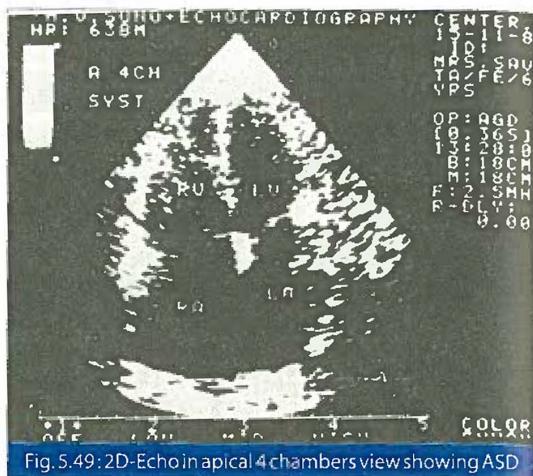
2D-Echo in apical 4 chambers view showing ASD
